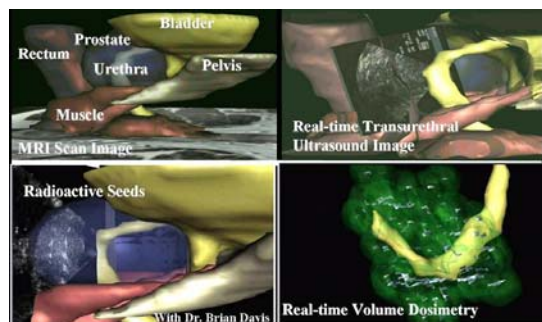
3D anatomical model of prostate and adjacent tissues computed from MRI scans to visualize tumors, guide optimal deposition of radiation seeds and facilitate on-line dosimetry.
